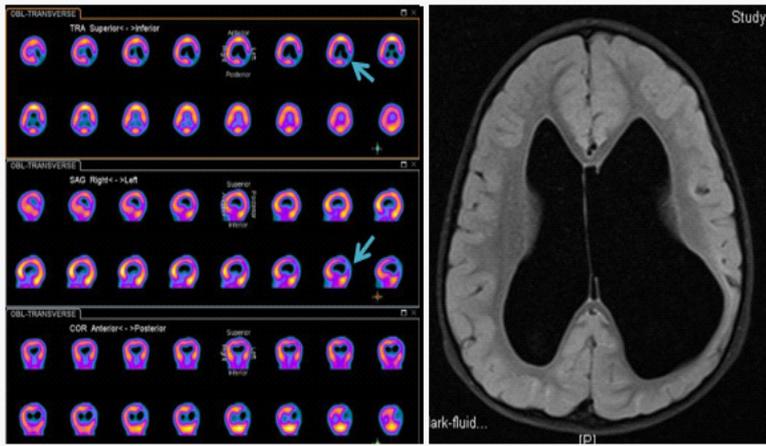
(1): seizure in a 3-year-old female patient with Chiari Malformation Type II. SPECT scan: Absent regional cerebral blood flow in left parietooccipital lobe. In addition, there was decreased regional cerebral blood flow in right occipital region
